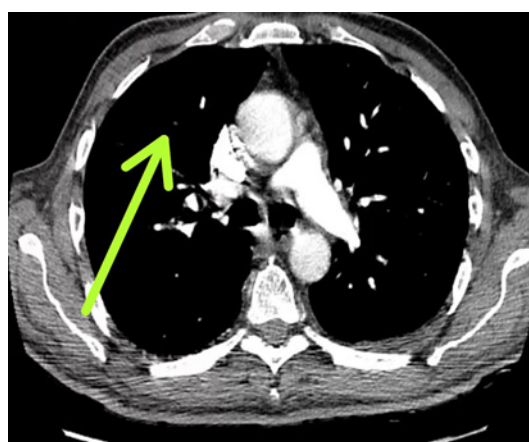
Angiogram CT showing the evidence of pulmonary embolism.
